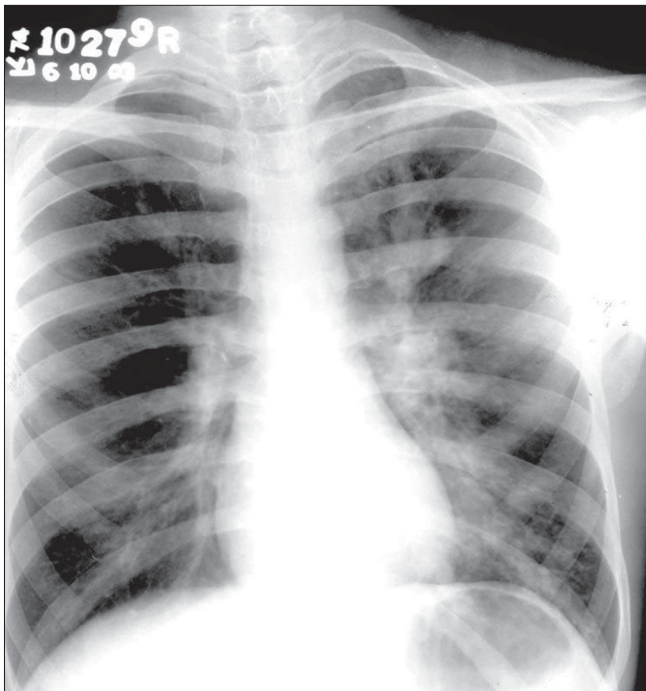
Chest radiograph – PA view
